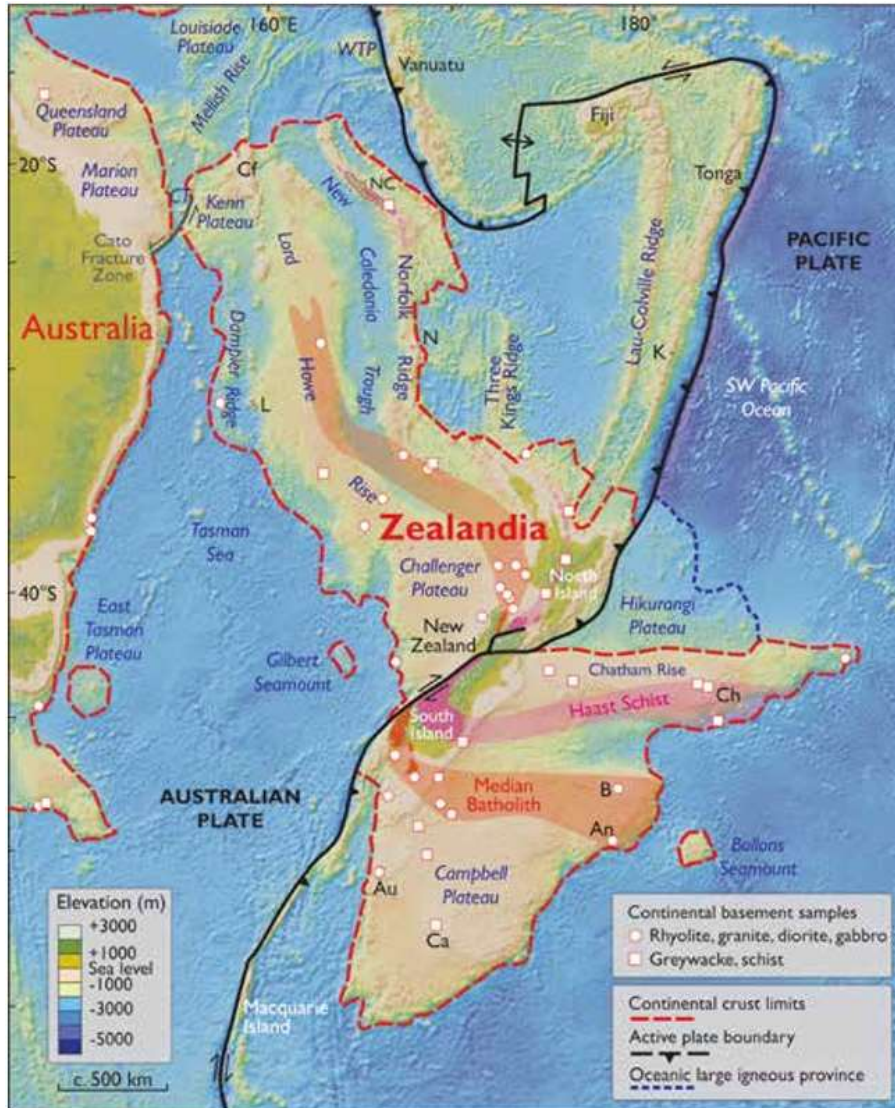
Spatial limits of Zealandia. Base map from Stagpoole (2002) based on data from Smith and Sandwell (1997). Continental basement samples from Suggate et al. (1978), Beggs et al. (1990), Tull-och et al. (1991, 2009), Gamble et al. (1993), McDougall et al. (1994), and Mortimer et al. (1997, 1998, 2006, 2008a, 2008b, 2015). NC—New Caledonia; WTP—West Torres Plateau; CT—Cato Trough; Cf—Chesterfield Islands; L—Lord Howe Island; N—Norfolk Island; K—Kermadec Islands; Ch—Chatham Islands; B—Bounty Islands; An—Antipodes Islands; Au—Auckland Islands; Ca—Campbell Island. Mercator projection.
